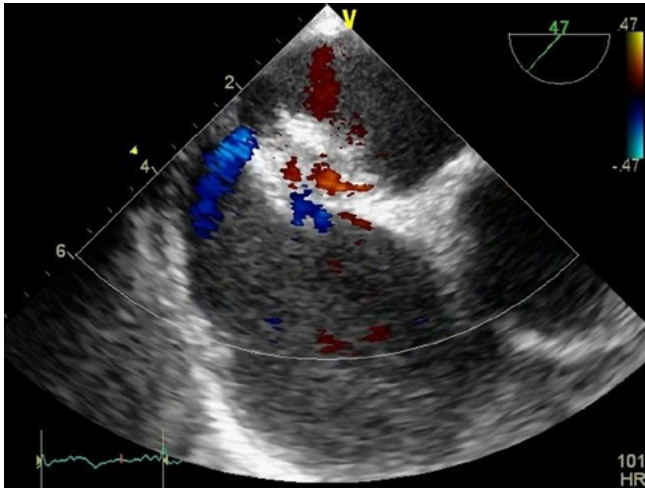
Transesophageal echocardiogram demonstrating a deployed occluding device in one of the atrial septal defects. A leak is present outside the perimeter of the device.
